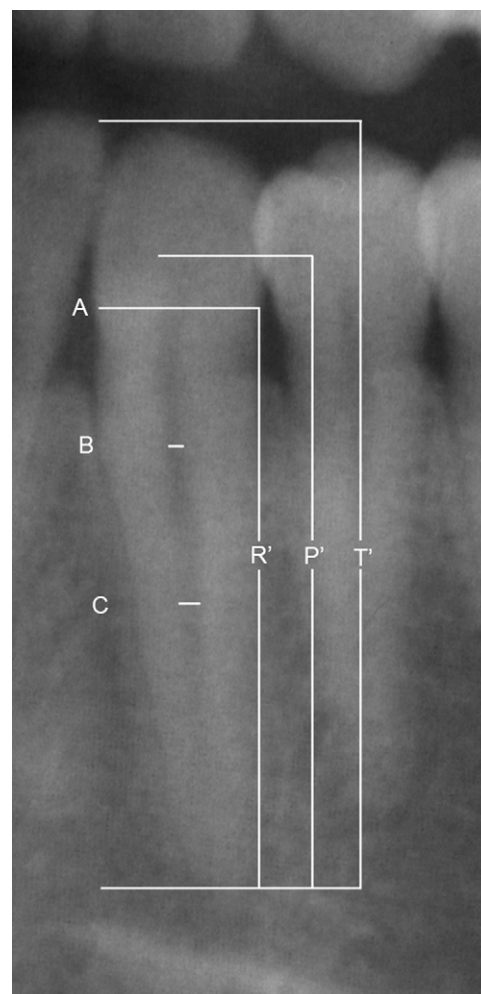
Measurements performed according to the method of Kvaal et al. [14] on panoramic radiograph.
